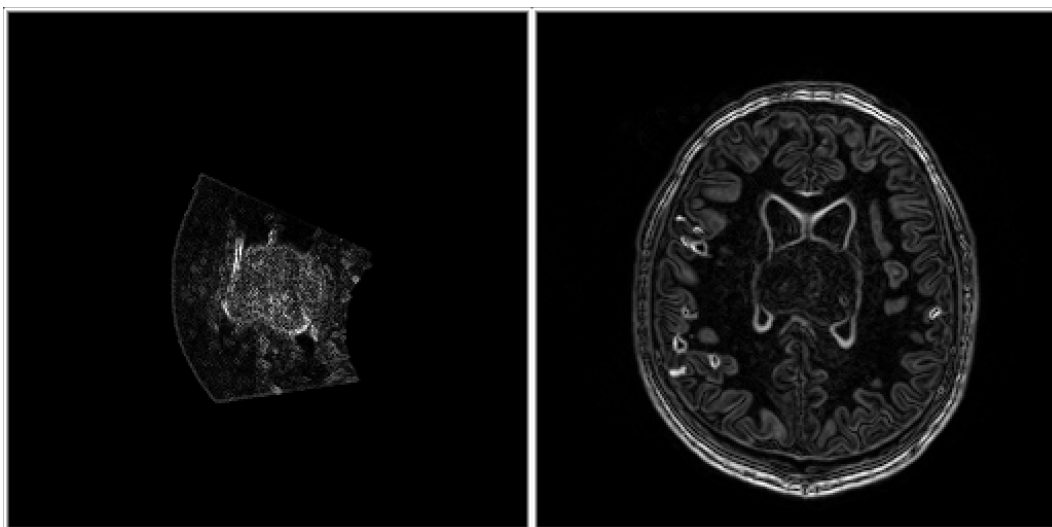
Corresponding slices from gradient magnitude filtered US (left) and MRI (right) volumes of the same patient.
